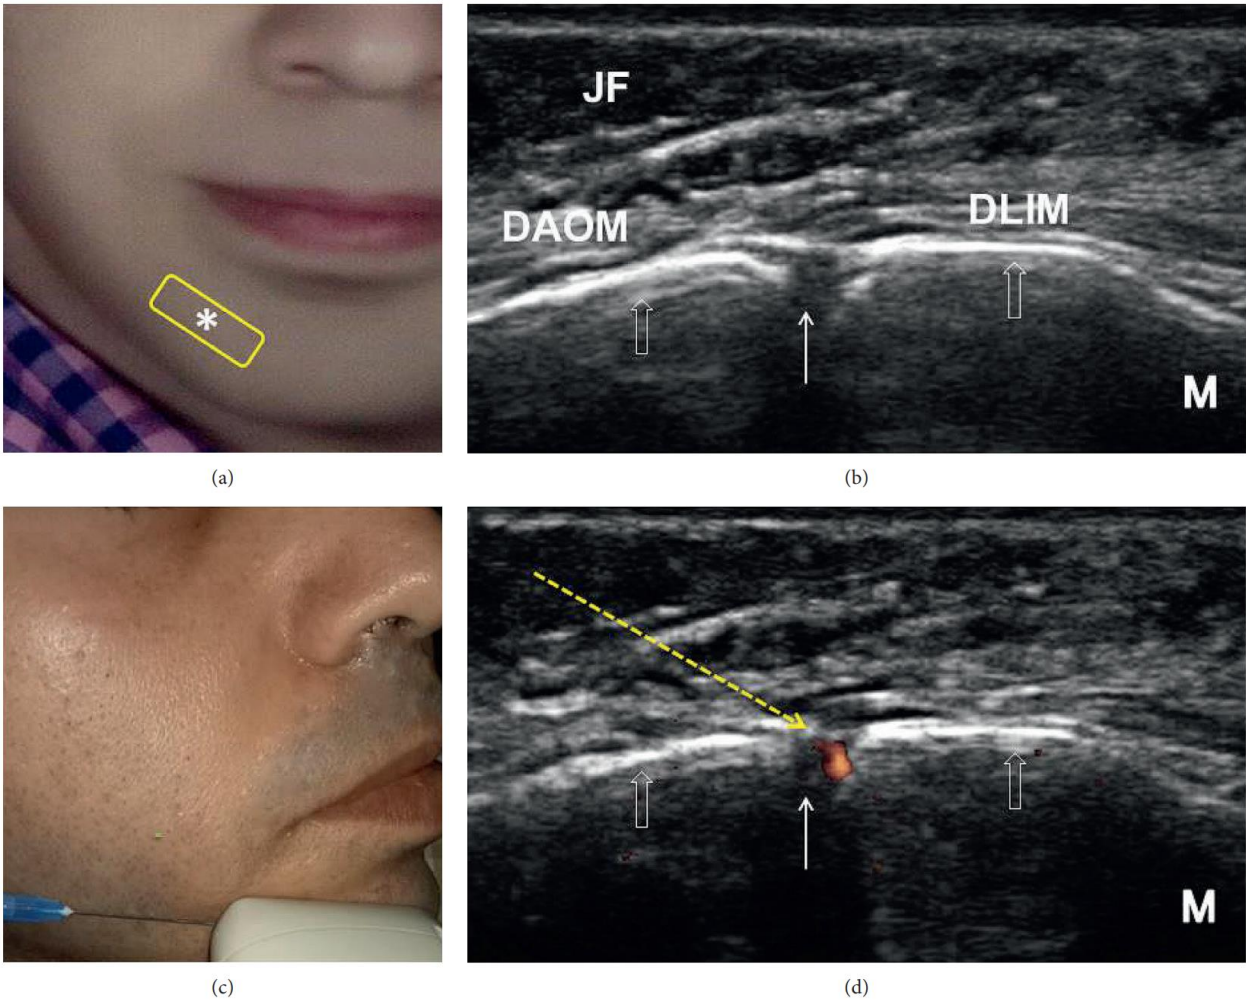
Sonoanatomy and ultrasound-guided injection technique for the mental nerve: (a) the transducer position (yellow rectangle), (b) ultrasound imaging of the mental nerve (white solid arrow), (c) introducing the needle from the lateral side toward the midline using the in-plane approach to target the mental nerve, and (d) power Doppler image used to identify the mental vessels. The empty white arrows denote the body of the mandible. The asterisk (*) denotes the mental foramen on the face. The yellow dashed arrow denotes the needle trajectory. DLIM: depressor labii inferioris muscle; DAOM: depressor anguli oris muscle; JF: jowl fat; M: medial side. All the pictures were obtained from the face of the first author.
